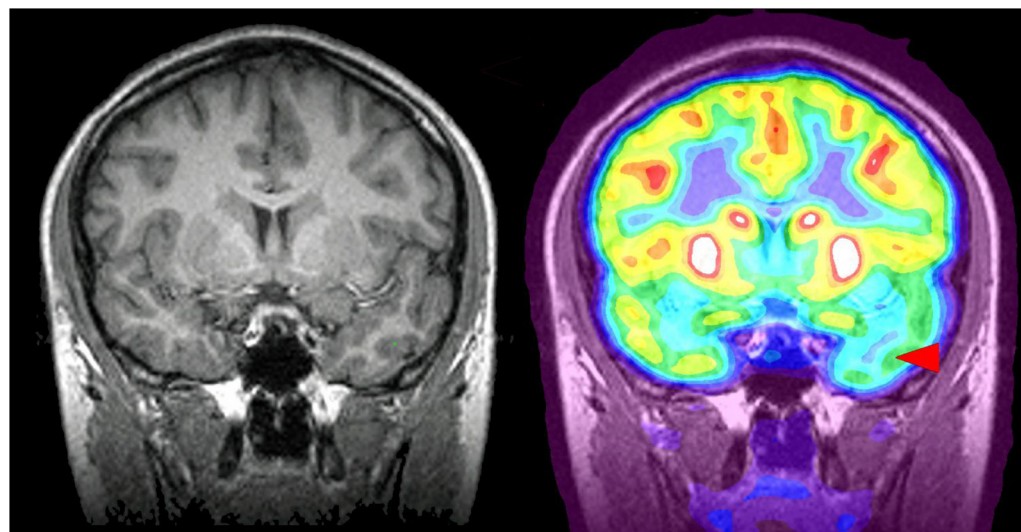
PET demonstrates decreased uptake in the left temporal lobe (red arrowhead), not visible on either standalone MR or MR concurrent with PET. Hippocampus and remainder of MRI study were normal. The patient had RNS to left frontal and temporal lobes and showed a decrease in seizures (Case #10). (For interpretation of the references to colour in the text, the reader is referred to the web version of this article.)
